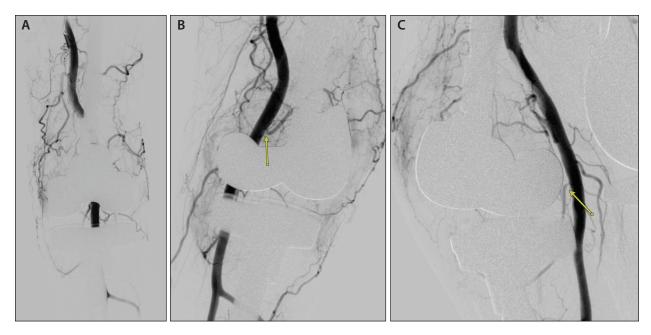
A patient with post–left TKA hemarthrosis. To optimize vessel visualization, CBCT was utilized. Initial anteroposterior SFA angiography revealed significant vascular hypertrophy, tortuosity, and hyperemia within the medial and lateral compartments of the left knee, without clearly demonstrating the origin of the genicular arteries (A). On CBCT scout DSA, a 36° right anterior oblique projection was determined to be ideal for visualizing the origin of the superior lateral genicular artery (yellow arrow, B), while a 32° left anterior oblique projection was selected to optimally visualize the origin of the inferior medial genicular artery (yellow arrow, C).
